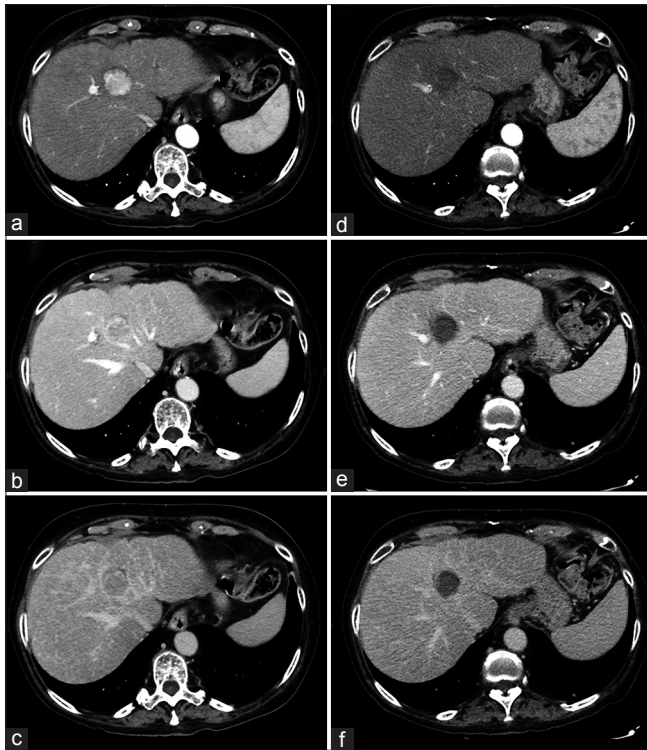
Abdominal computed tomography shows a 30-mm nodule with diffuse hyperenhancement in the arterial phase, and slow wash out in the portal and late phases (a-c). After 1 month, an abdominal computed tomography scan shows a large ablated area in the arterial, portal, and late phases (d-f)
